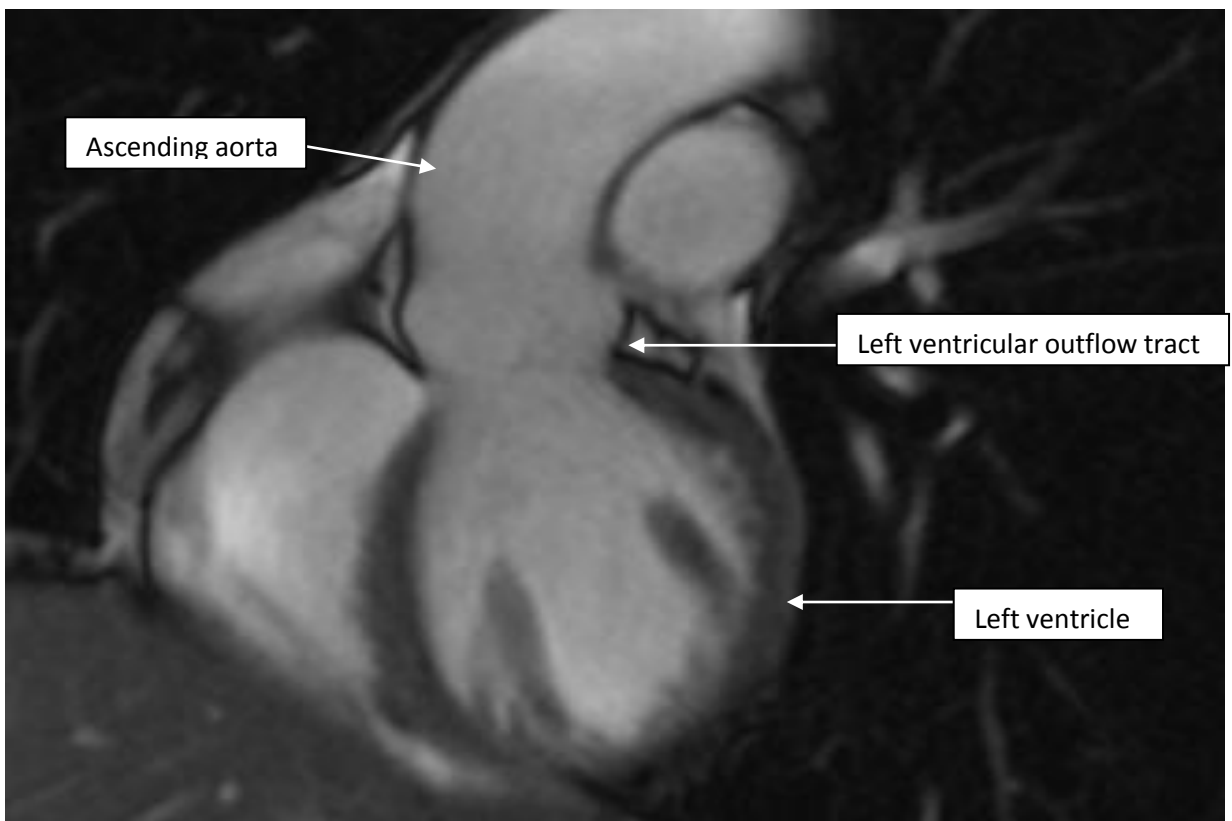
MRI CINE left ventricular outflow tract at systole
